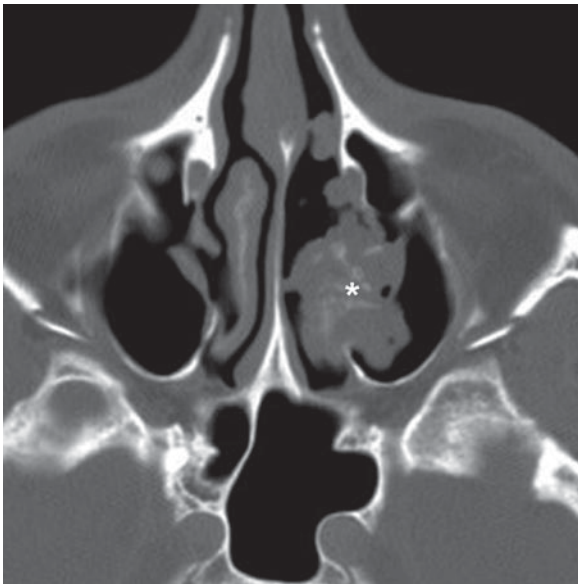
Inverted papilloma. Axial CT shows a lobular mass (*asterisk*) centered in the lateral nasal wall, with extension into both the nasal cavity and the maxillary sinus. The location, configuration, and central calcifications are all indicative of inverted papilloma
